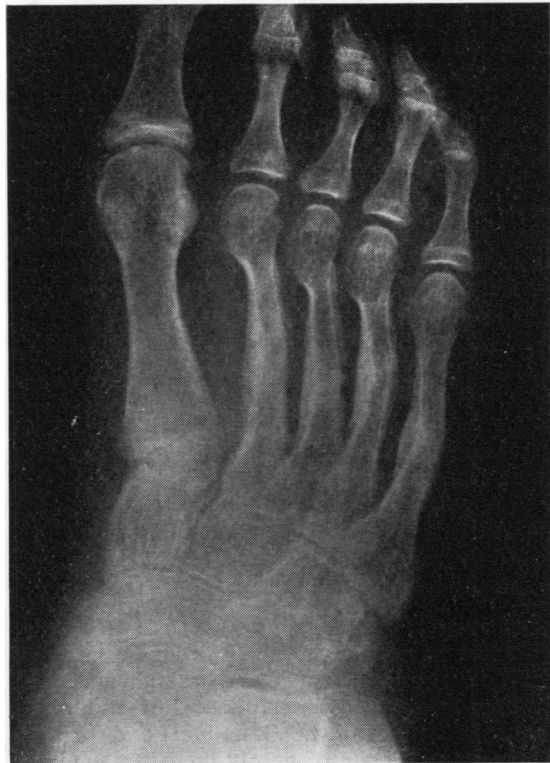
Case 1. Radiograph of foot showing multiple fractures and subperiosteal bone formation in several of the metatarsal bones.
